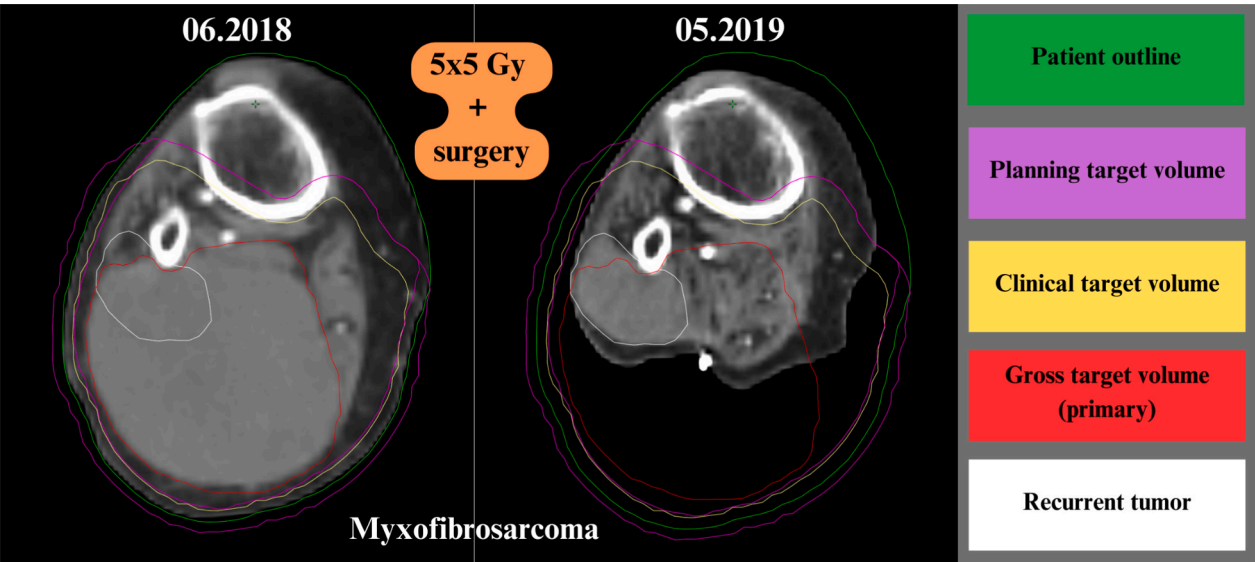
A registration of planning computed tomography with diagnostic imaging that revealed recurrence.
